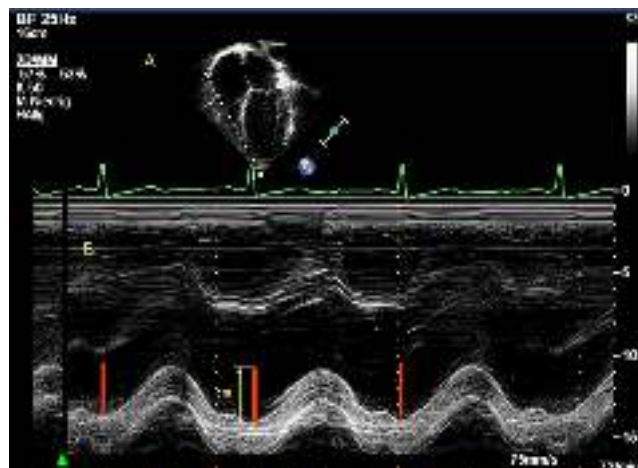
Apical 4-chamber view with M-mode image of the lateral MAPSE.
